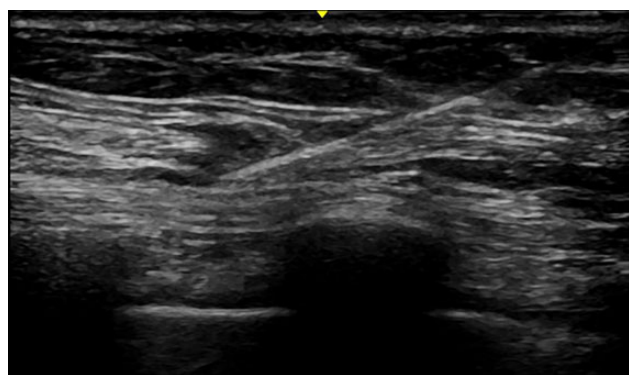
Ultrasound image of a superficial serratus plane block.
